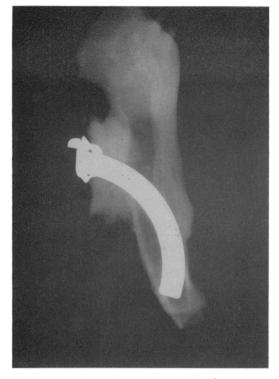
Postmortem roentgenogram demonstrating the mechanism of trauma from abutment of the tracheostomy tube against the anterior tracheal wall.
